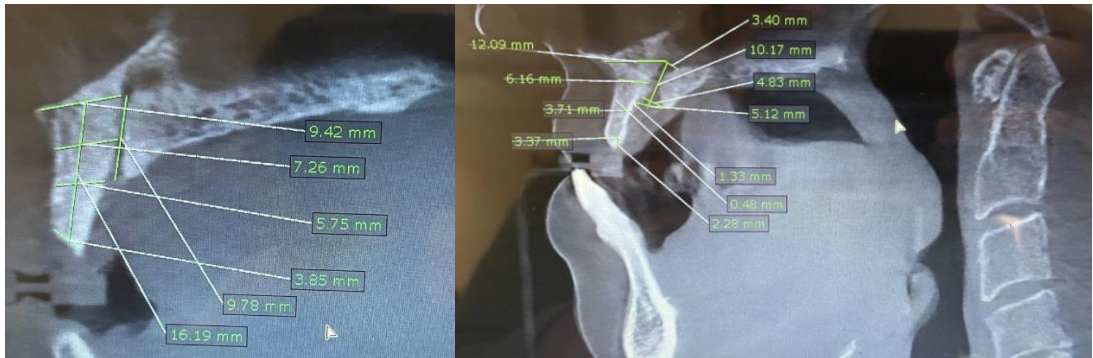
a: Linear analysis of Premaxilla outline in sagittal view of CBCT a) CRR outline b) PRR outline
